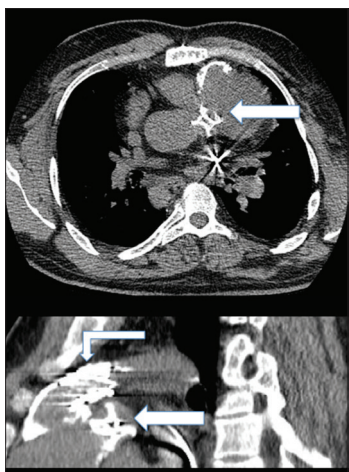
Computed tomography scan of the patient showing the AMPLATZER™ muscular ventricular septal defect occluder (arrow) in the native right ventricular outflow tract in axial (top) and sagittal (bottom) planes. The Melody® valve (elbowed arrow) is seen in the conduit anterior to the device
